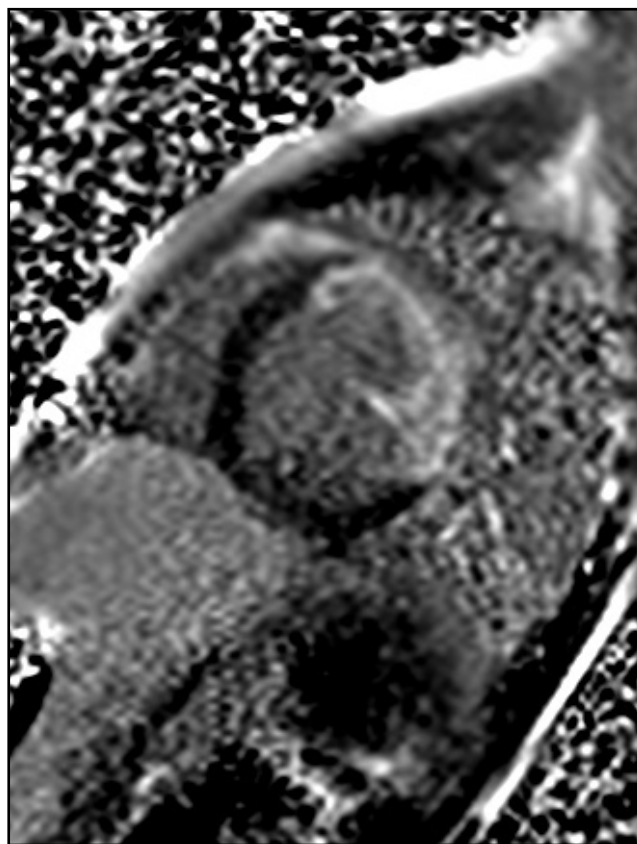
Magnetic resonance imaging with positive subendocardial late gadolinium enhancement in the anteroseptal and in anterolateral parts of left ventricle.
